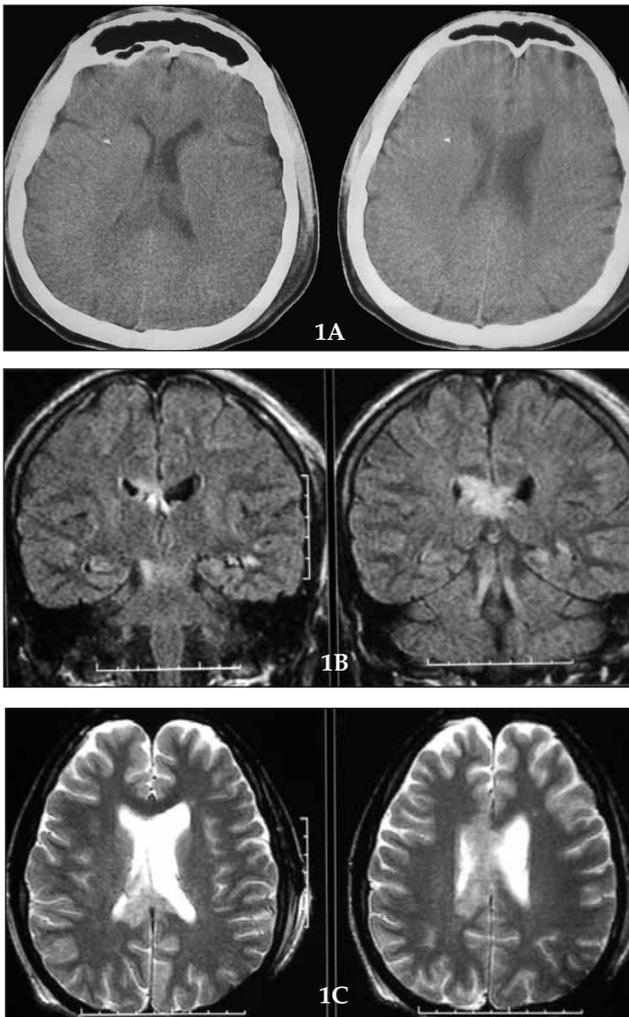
(A) Slices of tomography show only subgaleal edema on the left side but no parenchymal pathology. T1 (B) and T2 (C) slices of MRI of the same patient show diffuse axonal injury settled of corpus callosum without parenchymal edema.
